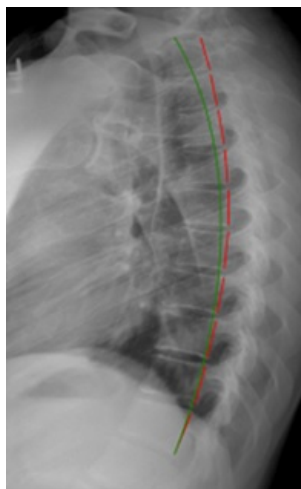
LT X-ray at 16-Month Follow-up. The green line represents the Normal Spinal Position and expected path of the posterior longitudinal ligament; the red line represents the patient's position known as George's Line. This is the path of the posterior longitudinal ligament.
